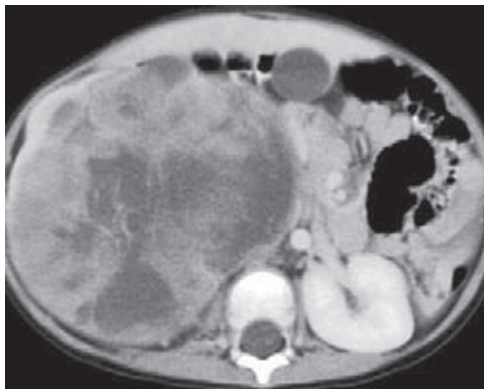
Mesoblastic nephroma (same patient as above). CT image shows a right renal mass of mixed attenuation
